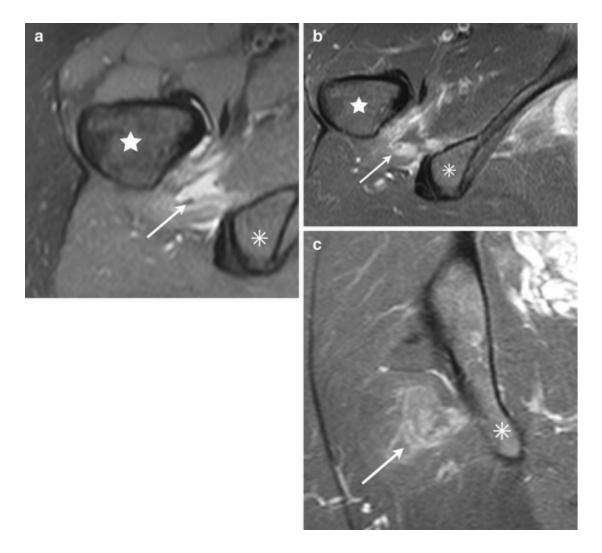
Axial fat-suppressed T2- (a), axial contrast-enhanced fat-suppressed T1- (b) and coronal fat-suppression T2-weighted (c) MRI show an area of high-signal intensity within the quadratus femoris (*white arrow*) and peripheral enhancement after gadolinium injection. Lesser trochanter–*star*; is chial tuberosity–*asterisk*
